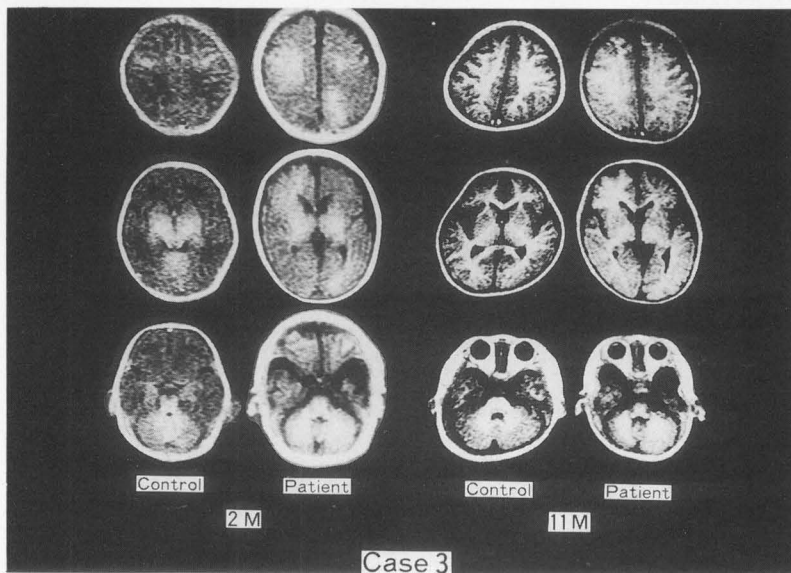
MRI on IR (2100/500) scans in case 3 disclosed high signal areas in the right front-parietal and left occipital lobes at two months old (Left), and asymmetry of the myelination of white matter at 11 months old
